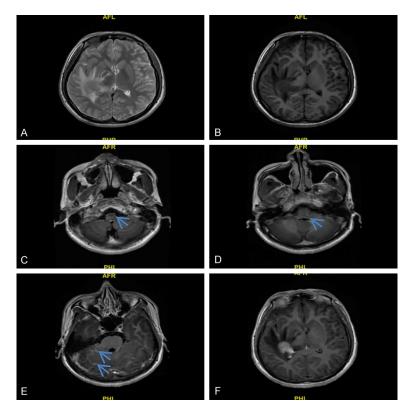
There is a mass lesion in the right temporal-occipital junction region, with a slightly high signal intensity on T2-weighted MRI (A) and slightly low signal intensity on T 1 (B). The lesion showed obvious inhomogeneous enhancement on contrast-enhanced T1-weighted (F), with the presence of peritumoral edema and enhanced multiple lesions in brain stem and cerebellar (C-E, blue arrow).
